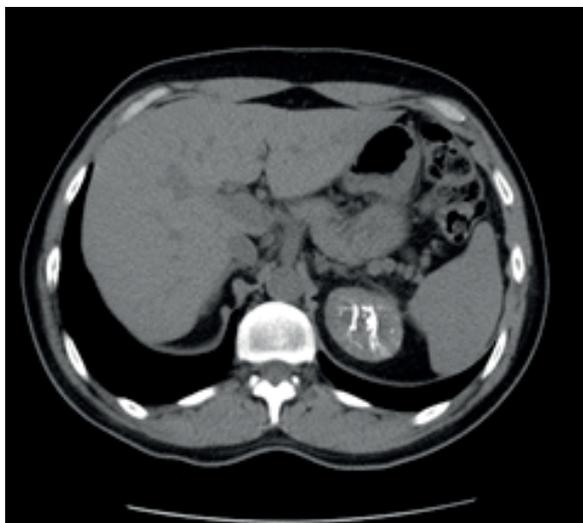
Four-month-follow-up with abdominal CT scan without IV contrast. Axial view.
